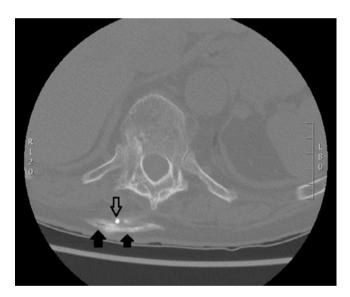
CT myelogram showing extravasation of contrast (dark arrows) from fractured intrathecal catheter (empty arrow) into subcutaneous space
